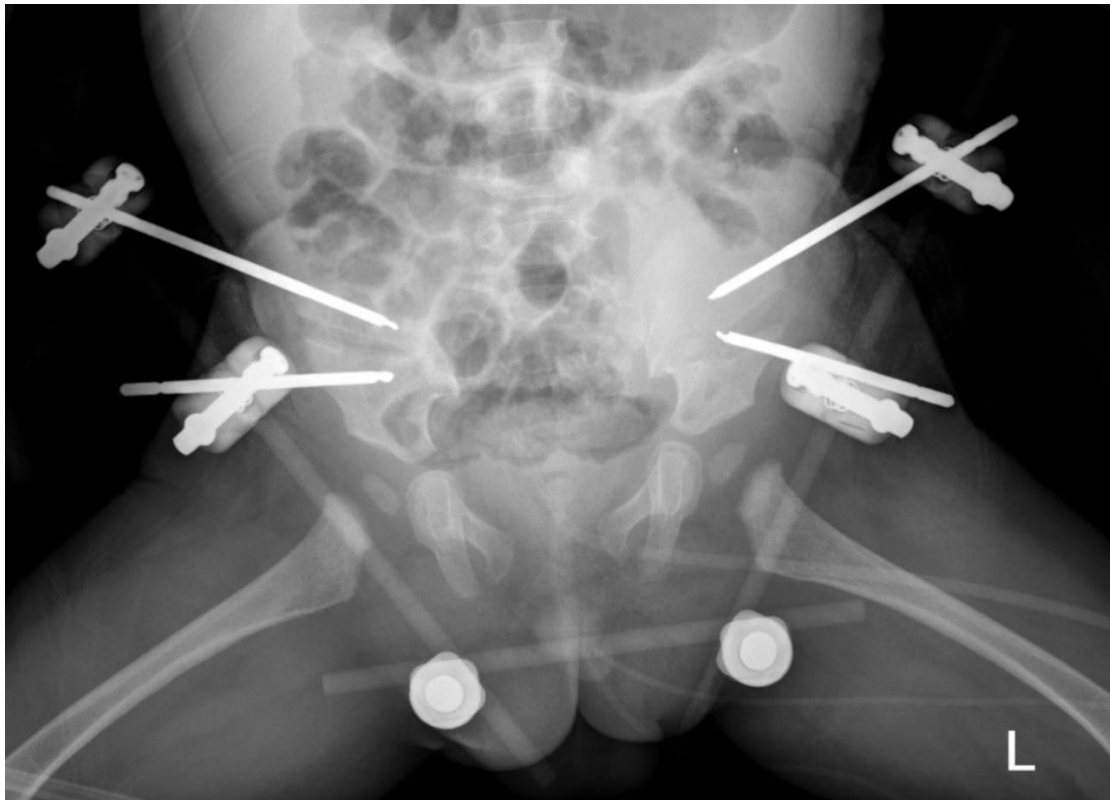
Post-op X-Ray AP Lateral View
